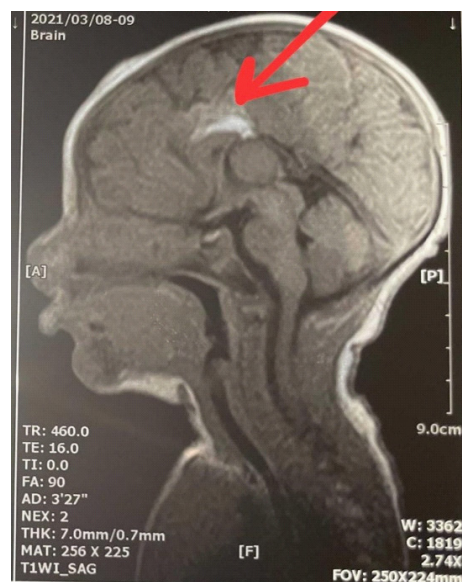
Sagittal section of MRI head with a red arrow showing lipoma of the corpus callosum.
